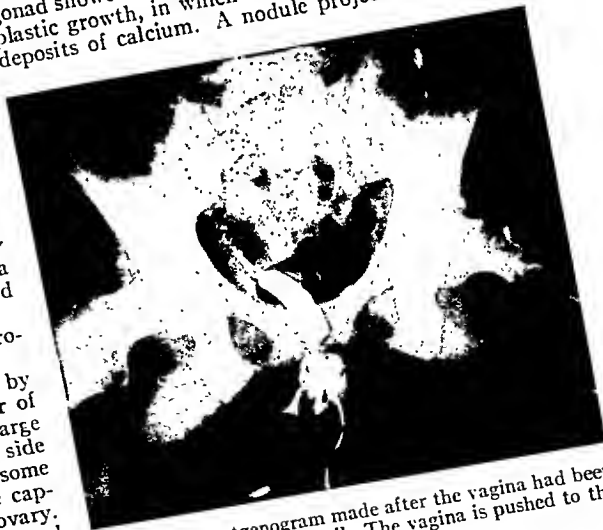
Roentgenogram made after the vagina had been distended with iodinated oil. The vagina is pushed to the right by the large tumor.
